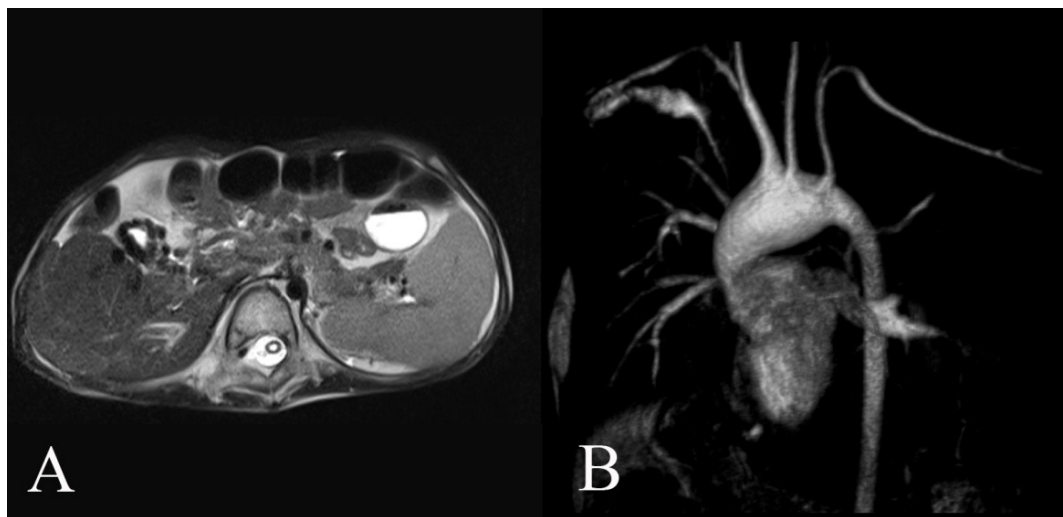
MRI of the abdomen and the heart. (A) Transverse T2W abdominal tomograms showing cavernous portal vein transformation and dilated portosystemic collateral blood vessels in the cholecystic lobe in the form of low IS (“flow void” structures in the blood vessels) and subsequent splenomegaly; (B) MR of the aortic arch (contrast aortography). Fusiform dilatation of the ascending aorta, aortic arch, and part of the isthmic region with a maximum diameter of 34 mm.
